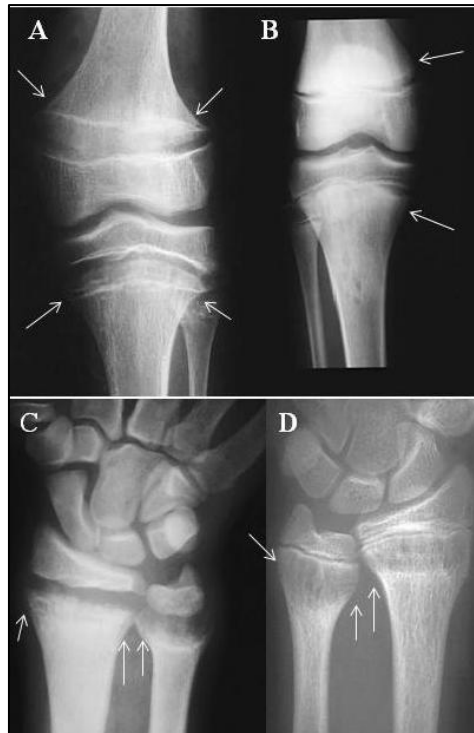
A and B: radiographs showing widening and cupping of long bone epiphyses due to rickets (knees of adolescents with high and mild vitamin D deficiency); C and D: wrist of an individual with vitamin D deficiency before and after treatment (from Adams, 2005:Figures 2-3)
